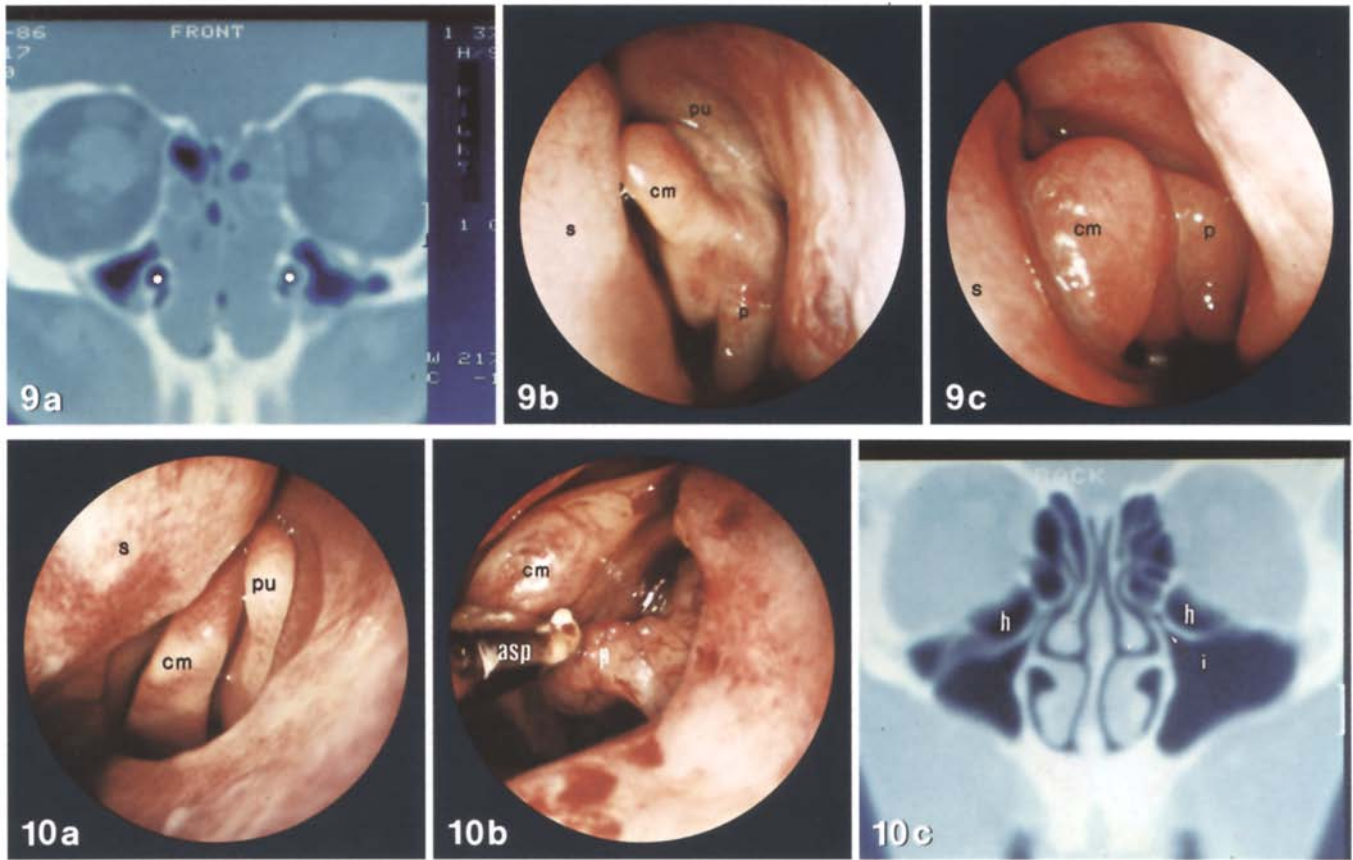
a CT scan of patient with massive nasal polyposis and recurring maxillary sinusitis. There is only minimal swelling of the mucosal lining of the maxillary sinuses at the moment, but disease in the ethmoids is clearly present. *Asterisks* indicate nasolacrimal duct. b, c View into the left middle meatus in cases of polyposis. b A more isolated polyp protrudes from the contact area between the uncinate process and the middle turbinate. More polyps originated from the sinus of the turbinate and the anterior face of the ethmoidal bulla. c More pronounced nasal polyposis: the mucosa of the head of the middle turbinate shows polypoid change and there are polyps protruding from the middle meatus. *s*, Septum; *cm*, concha media; *pu*, uncinate process, *p*, polyps
